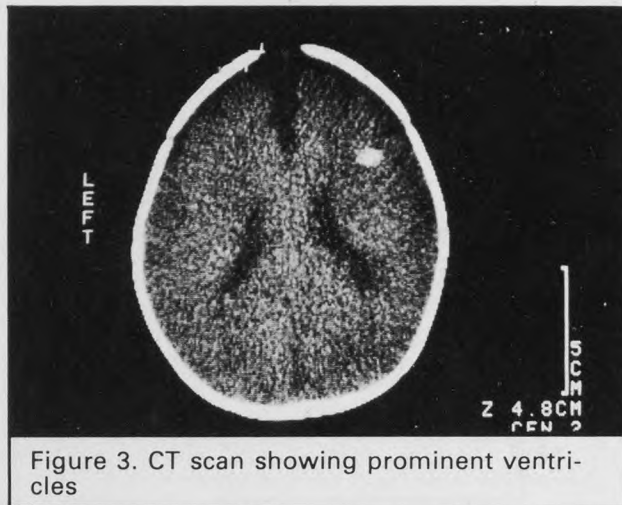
CT scan showing prominent ventricles
